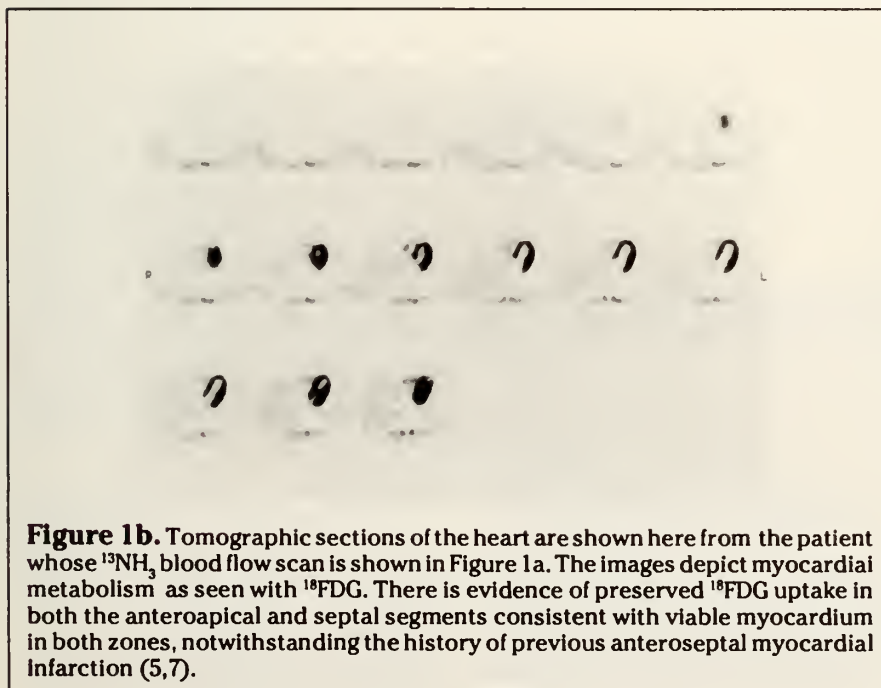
Tomographic sections of the heart are shown here from the patient whose $^{13}\text{NH}_3$ blood flow scan is shown in Figure 1a. The images depict myocardial metabolism as seen with ^{18}F FDG. There is evidence of preserved ^{18}F FDG uptake in both the anteroapical and septal segments consistent with viable myocardium in both zones, notwithstanding the history of previous anteroseptal myocardial infarction (5,7).
